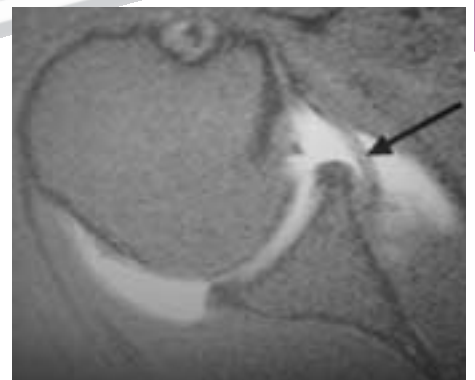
Magnetic resonance image showing Bankart lesion (arrow).
